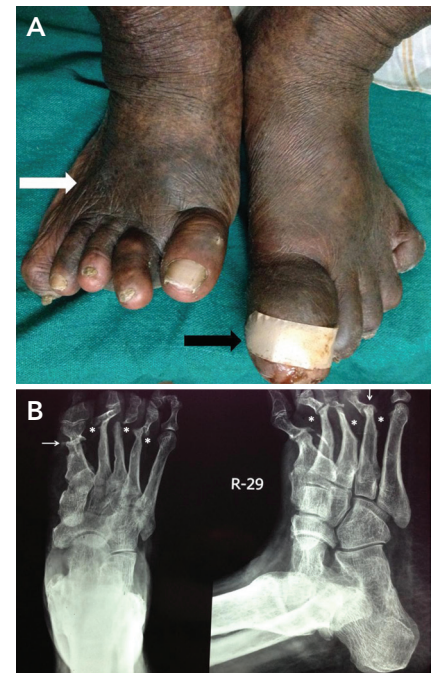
Case 1. *A*) Swelling of left great toe with discharging wound (black solid arrow) and right-sided fore-foot widening (white solid arrow). *B*) X-ray of the right foot showing “pencil-in-cup deformity” (white arrow) and “sucked-candy appearance” (*) suggestive of pattern I CF.
